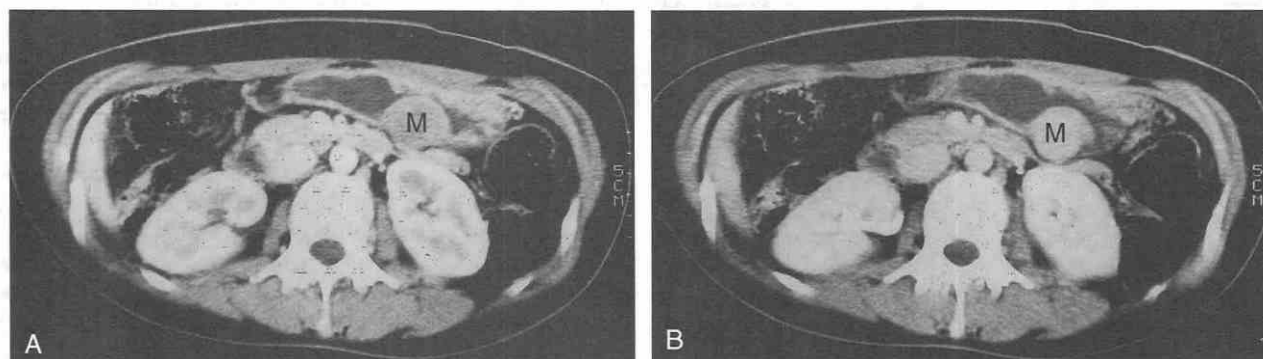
Benign gastrointestinal stromal tumor (M) of the stomach with poor contrast enhancement in the early phase (A) of the dynamic CT study and marked enhancement in the delayed phase (B).
